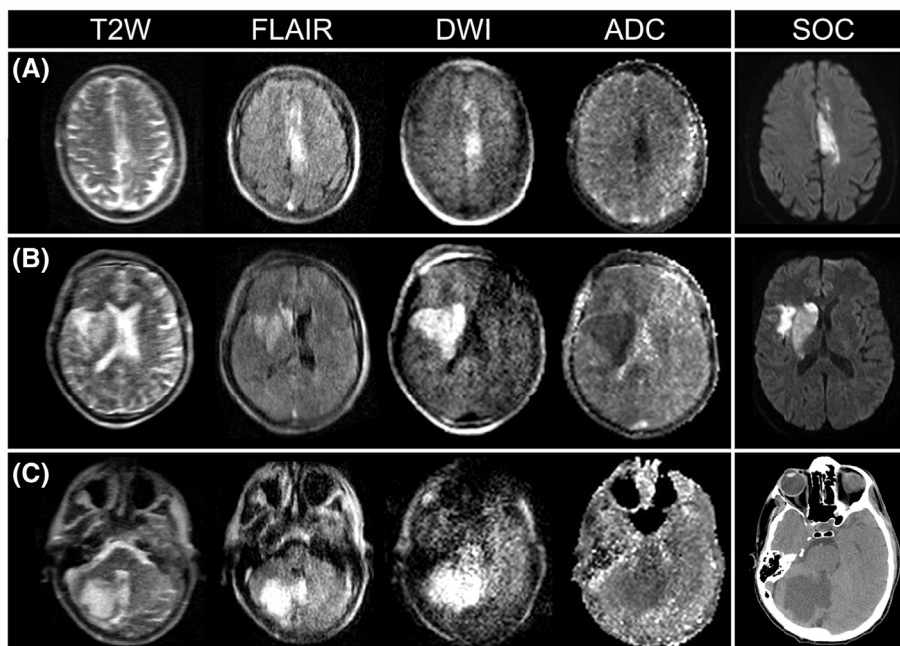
Panel of multiple images comparing low-field MRI at 0.064 T (parametric MRI [pMRI]) using Hyperfine Swoop imaging compared with standard care (SOC) capturing ischaemic infarcts in multiple brain regions. (A) The pMRI and SOC (1.5-T) images (32 and 29 h since last known normal, respectively) of a 65-year-old male with a left anterior cerebral artery stroke. (B) The pMRI and SOC (1.5-T) images (29 and 12 h since last known normal, respectively) of a 61-year-old male with a right middle cerebral artery stroke. (C) The pMRI and SOC computed tomography (CT) images (44 and 32 h since last known normal, respectively) of a 57-year-old male with a right cerebellar stroke. SOC examinations included MRI (diffusion-weighted imaging [DWI] sequence) and CT. Images are from Yuen et al.⁹¹ T2-weighted imaging (T2W), fluid attenuated inversion recovery (FLAIR) and apparent diffusion coefficient (ADC).
